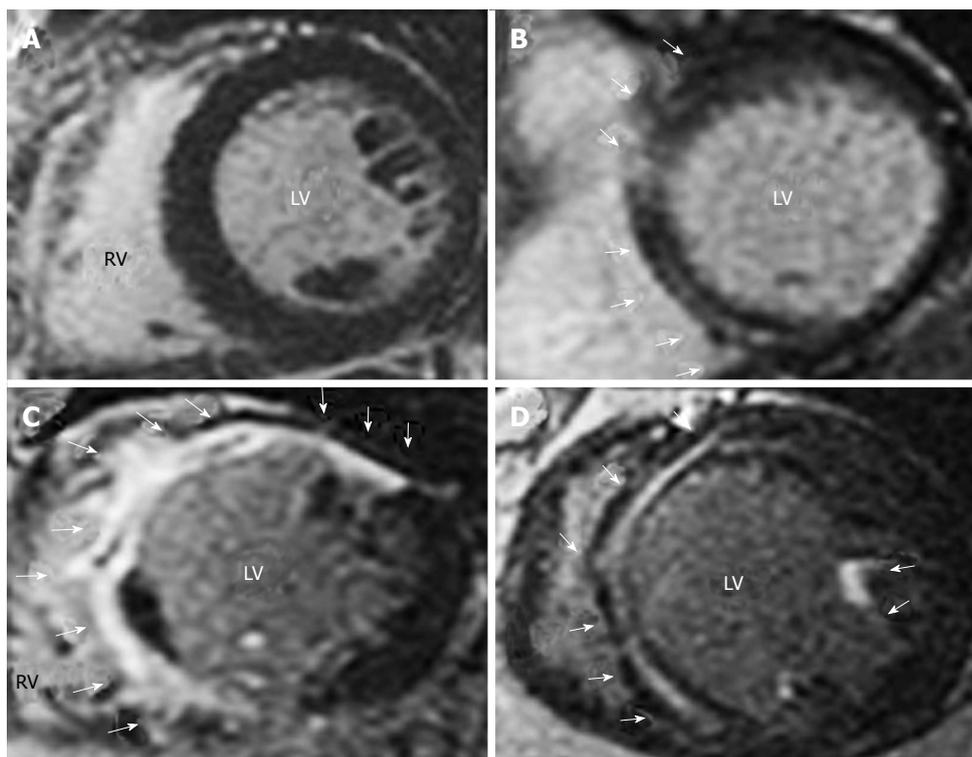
Representative short axis late gadolinium enhancement-cardiac magnetic resonance images in patients with dilated cardiomyopathy. A: No LGE; B: localized LGE. Mid-wall LGE distributed only into anterior and inferior septum; C: Extensive LGE. LGE distributed at anterior and inferior septum, anterior, antero-lateral and inferior LV segments; D: Extensive LGE. Mid wall LGE distributed at anterior and inferior septum, and at anterior papillary muscle. Arrows indicate LGE in LV wall segments. All the images are taken from Machii *et al*^[13] with permission. LGE: Late gadolinium enhancement; LV: Left ventricular.
